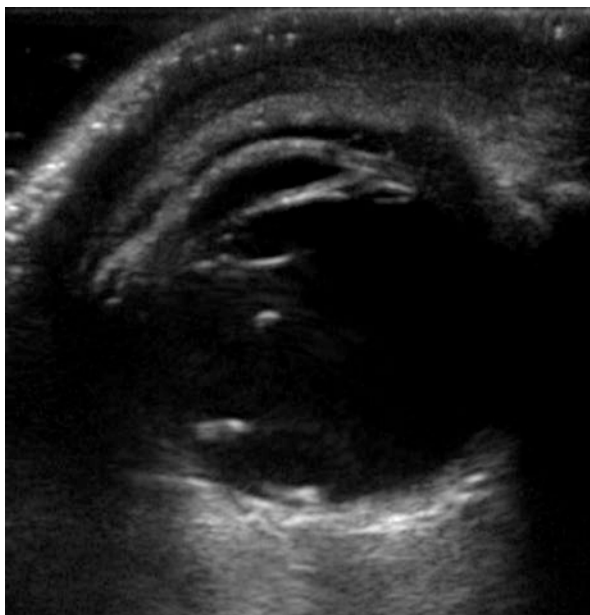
Orbital ultrasound demonstrated multiple foreign bodies in the posterior chamber
